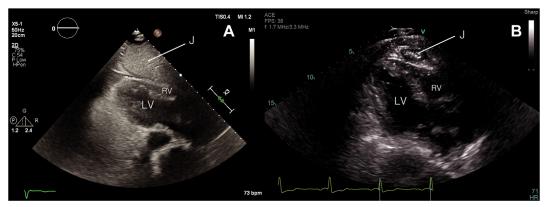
Parasternal long-axis view on TTE during the ED presentation (A) compared with a prior study (B). (A) The dilated jejunum (J) is now causing a near-total collapse of the right ventricle (RV). (B) Normally, the undilated J can be found as a multilayered tubular structure anterior to the RV. *LV*, Left ventricle.
